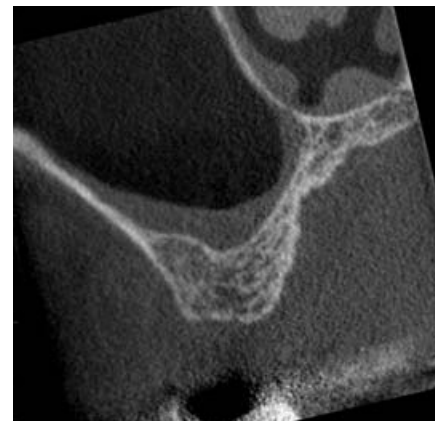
Axial CBCT image
